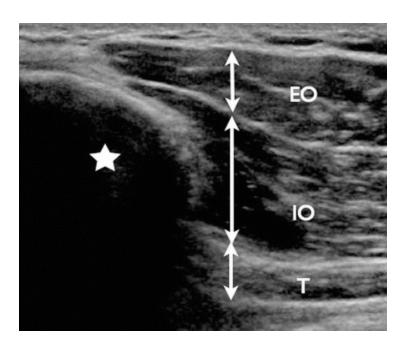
Normal transverse ultrasound image with a 17–5 MHz transducer shows normal abdominal wall anatomy at the level of the iliac crest (*arrow*). *EO* external oblique, *IO* internal oblique, *T* transverse muscle
